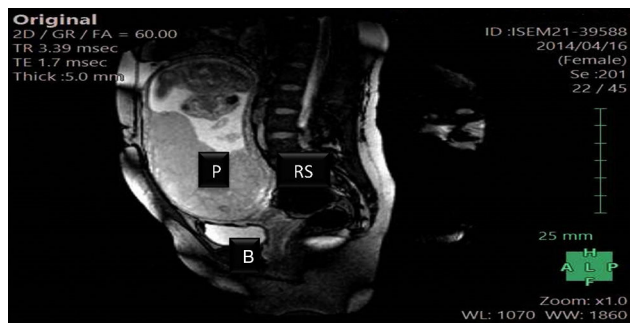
Nuclear magnetic resonance image. P: placenta; RS: recto sigmoid; B: bladder.
